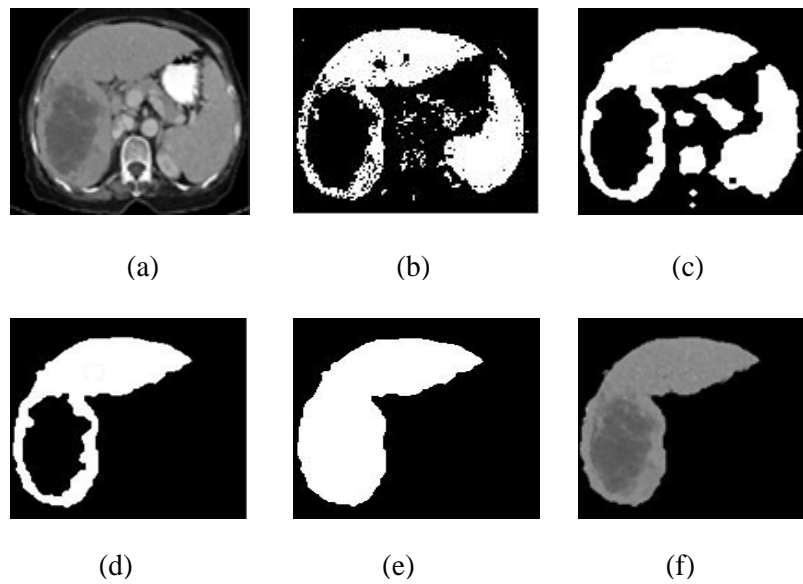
Liver Segmentation (a) Abdominal CT Image (b) Thresholding (c) Morphological Processing (d) Largest Region Extracted (e) Hole Filling (f) Segmented Liver
